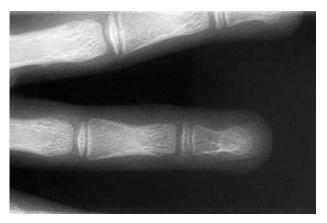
The radiograph shows a defect of the distal phalangeal bone. The radiographs suggest a subperiosteal localisation. Dorsal view.
